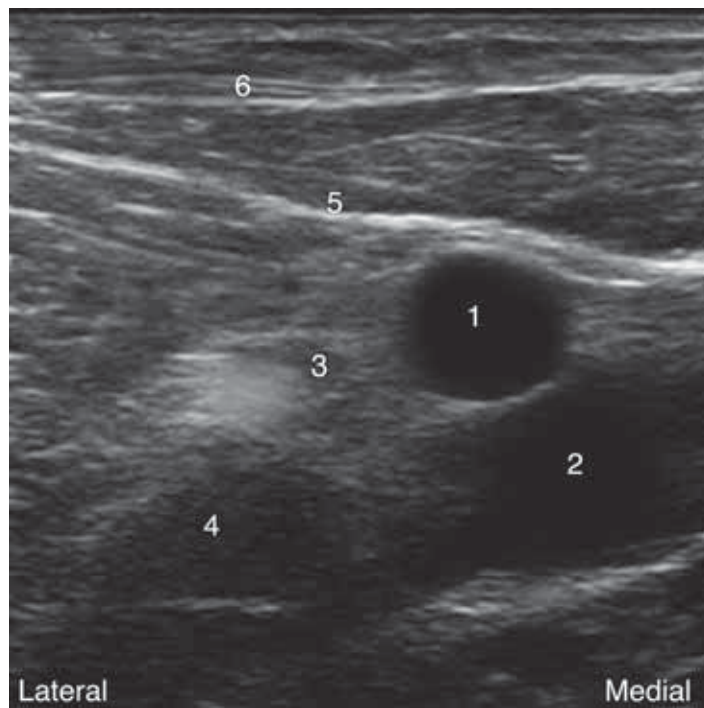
Transverse sonogram of femoral nerve area. 1 = Femoral artery; 2 = Femoral vein; 3 = Femoral nerve; 5 = Fascia iliaca; 6 = Fascia lata.
